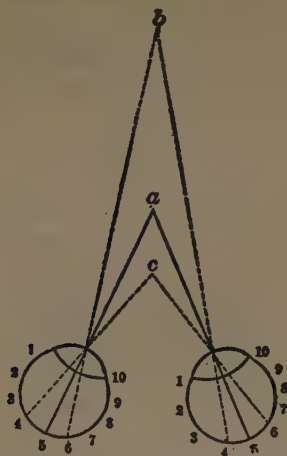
WHILE FIXATING "A" IT IS SEEN SINGLY WHILE "B" AND "C" ARE SEEN DOUBLED, BECAUSE THEIR RESPECTIVE OPTICAL IMAGES DO NOT FALL ON CORRESPONDING POINTS OF THE RETINA.
